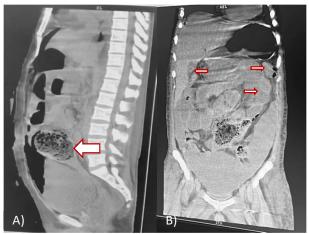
A) Computed tomography of sagittal section which shows dilation of the ileocecal valve with abundant coprostasis (arrow), air-fluid levels and free air in the abdominal cavity. B) Coronal cut computed tomography showing free air in the abdominal cavity (arrows) and coprostasis at the level of the ileocecal valve.
